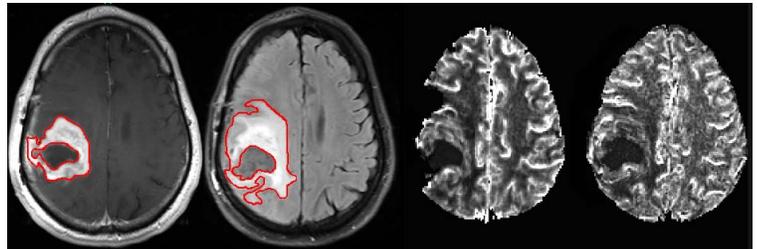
Enhancing tumor and FLAIR hyperintensity outlined manually on representative images along with CBF maps from GE and SE MRI.
